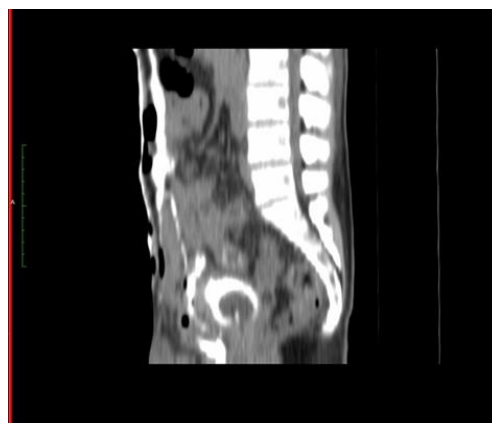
A 34-year-old male who fell from a height suffered pelvic fractures. Patient presented with hematuria & urinary incontinence. Reconstructed sagittal image of a CT cystogram shows contrast extravasation into the extraperitoneal perivesical space. It is also seen extending along the anterior abdominal wall. Images are consistent with extraperitoneal bladder injury. CT also showed fracture of superior pubic rami.
